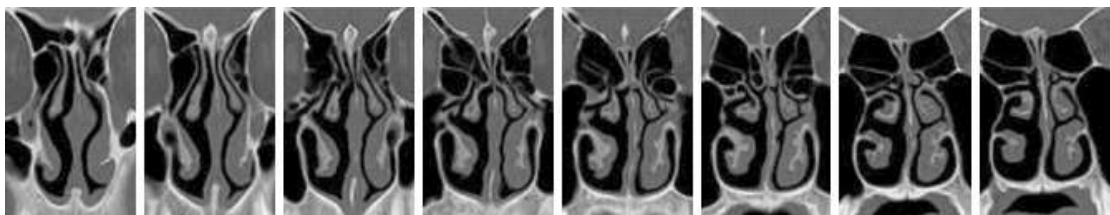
The continuous coronal CT image of healthy nasal cavity.
